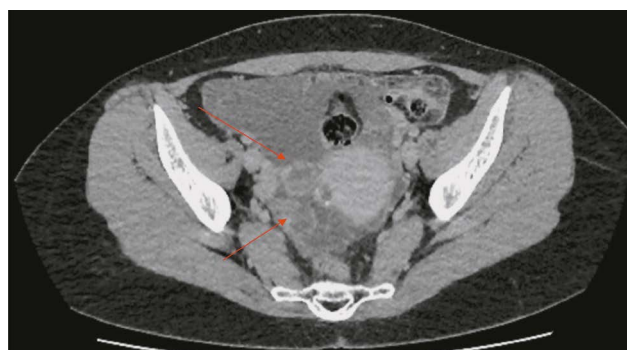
Pelvic computed tomography (axial view). Rounded cystic and solid lesions (indicated by red arrows) and free fluid (ascites) are visible in the right ovarian area.
